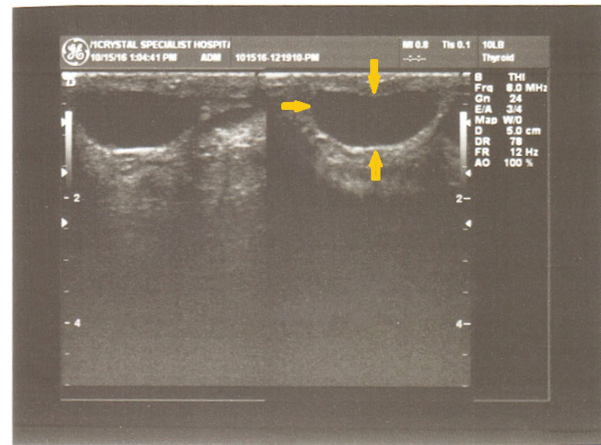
Ultrasound image demonstrates a type 3 complex breast mass. In homogenous sonopenic lesion with a micro-lobulated margin and “cloud” echo appearance. Multiple carcinomas in a single breast viewed through a hand-held 8.0 MHz_e transducer/probe.
